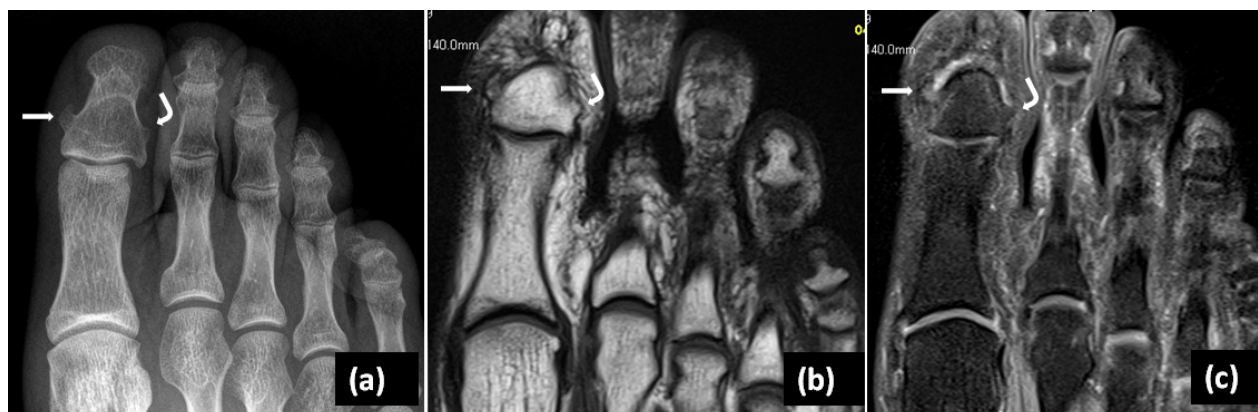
Enlarged views of anteroposterior radiograph of the left foot (a), axial T1-weighted (b) and postcontrast fat-suppressed T1-weighted (c) MR images showing medial (arrow) and lateral (curved arrow) exostosis of the distal phalanx at the base of the great toe in a 46-year-old female patient who complains of pain at this location. Note the slight enhancement at the medial exostosis on postcontrast fat suppressed axial T1-weighted image (c).
